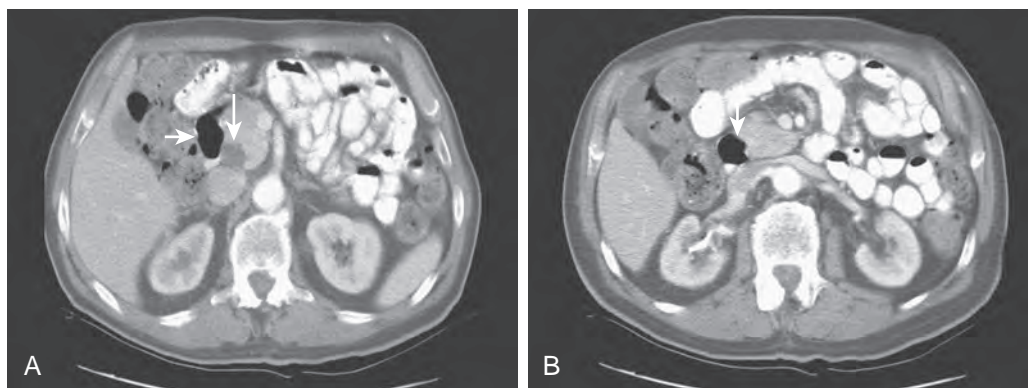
Duodenal diverticulum mimicking a cystic pancreatic neoplasm on CT. A. CT scan with oral and intravenous contrast material at the level of the pancreatic head shows a fluid-filled cystic lesion (long arrow) that was initially thought to represent a cystic pancreatic tumor. Note air and contrast material in the duodenum (short arrow). B. A follow-up CT scan at a similar level 6 months later shows filling of the diverticulum with gas (arrow), confirming the diagnosis of a duodenal diverticulum. (From Macari M, Lazarus D, Israel G, et al: *Duodenal diverticula mimicking cystic neoplasms of the pancreas: CT and MR imaging findings in seven patients*. *AJR* 180:195-199, 2003.)
